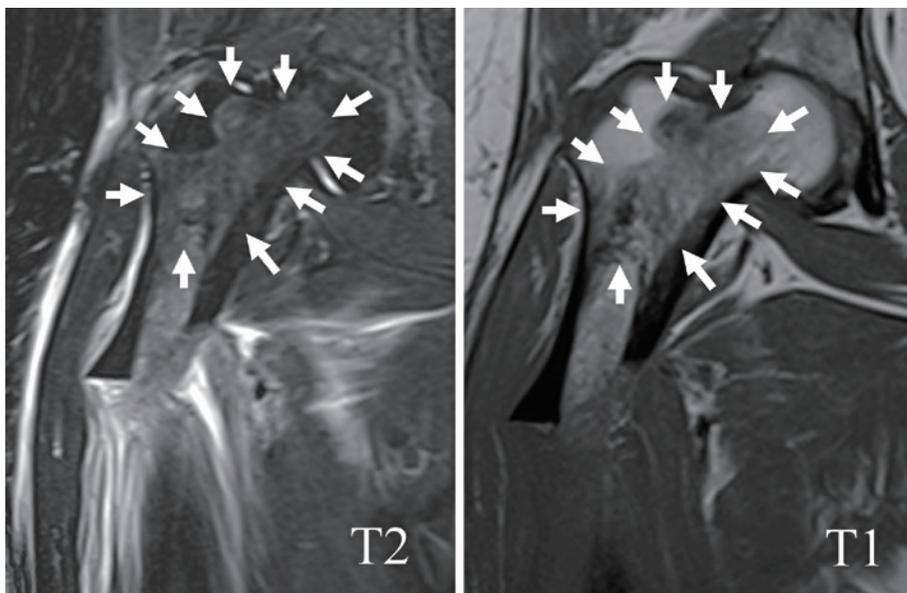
Magnetic resonance imaging before surgery demonstrated a tumor lesion at the trochanter (arrows). The lesion was demonstrated a low intensity on T1WI and iso intensity on T2WI.
